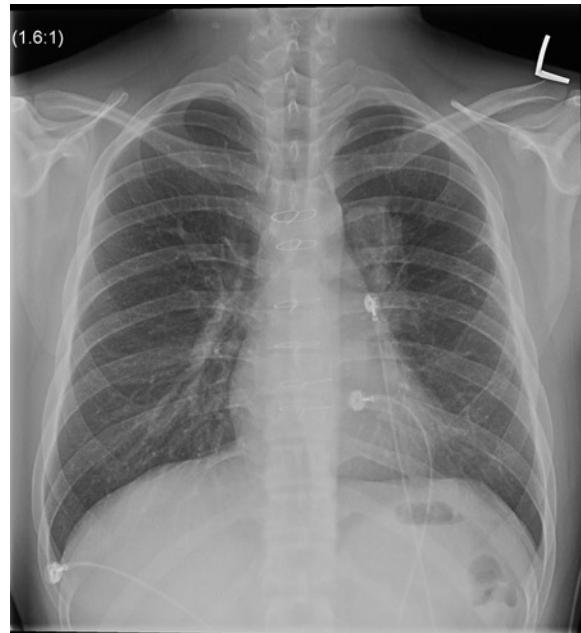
Chest X-ray taken before surgery.
